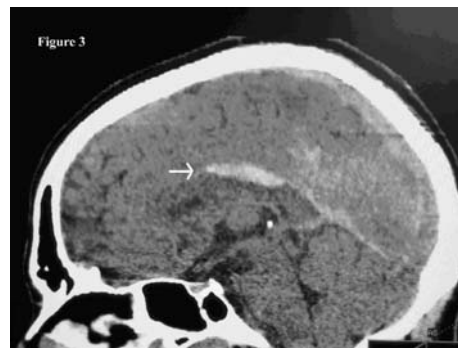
Non-contrast CT of head sagittal section showing callosal and pericallosal bleed.
